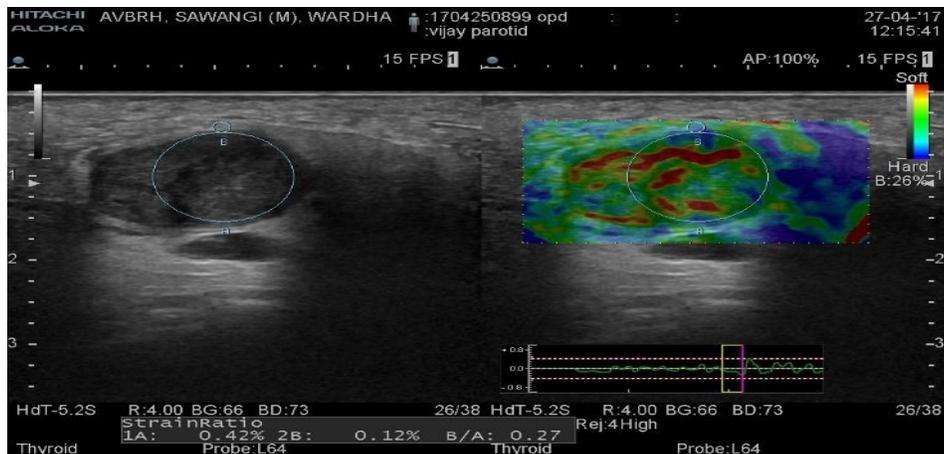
Ultrasonography and Elastography images showing hypoechoic echogeneity on ultrasound and Elastographic Score (ES) 1 on Elastography.
